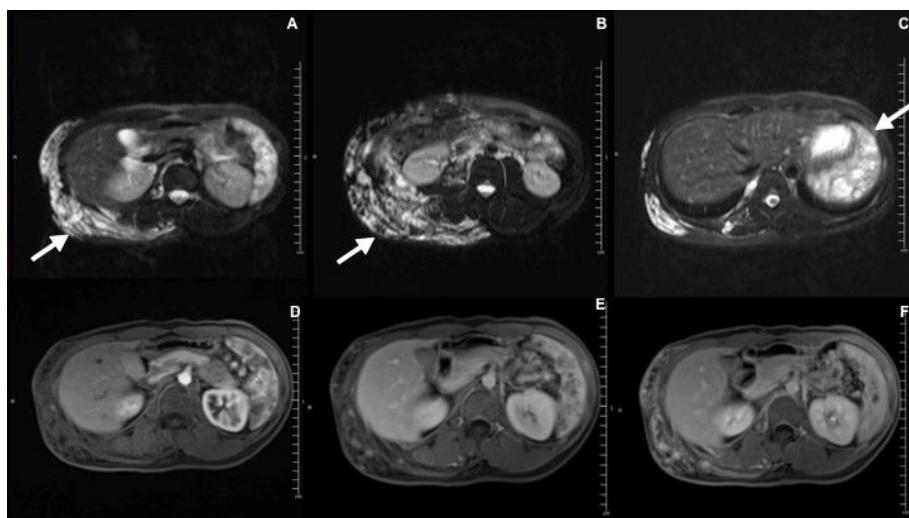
Upper abdominal contrast MRI
